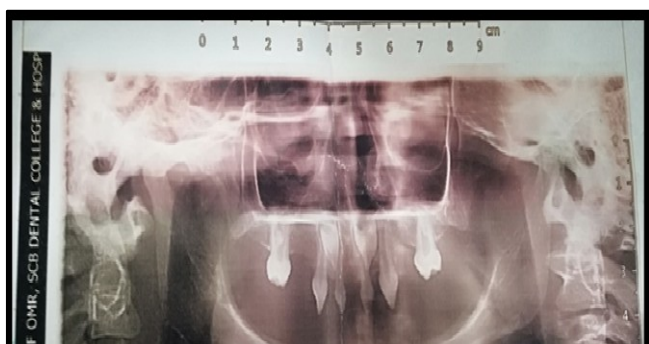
Panoramic radiograph findings
